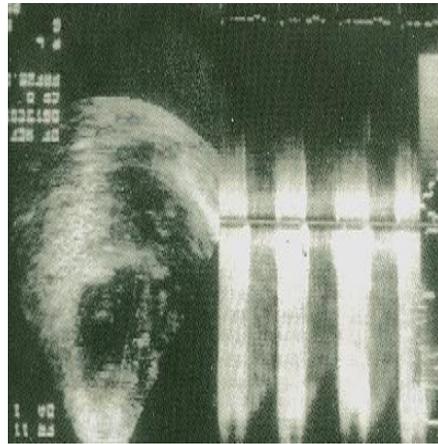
Continuous Doppler signals across the constriction
